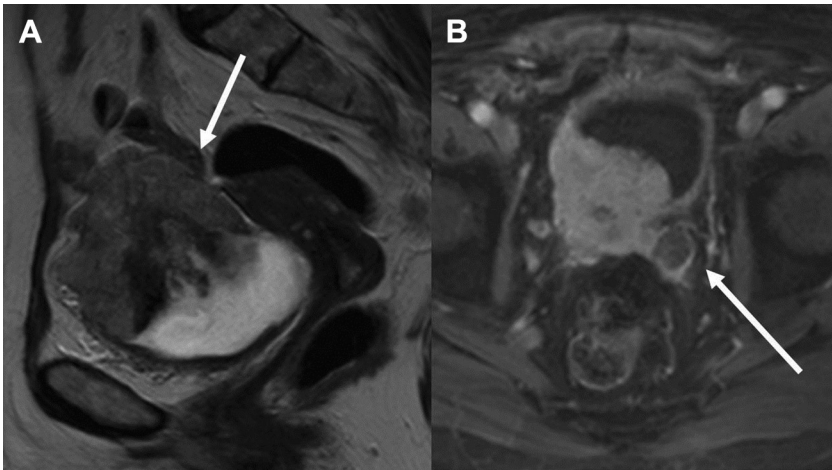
T2-weighted (A) and T1 FS postcontrast (B) axial images. The *arrows* indicate small bowel involvement in keeping with T4a tumor.
